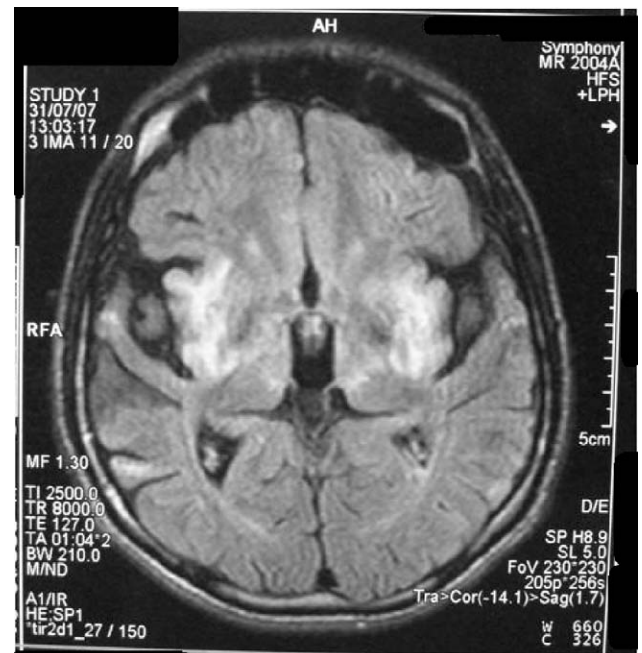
The axial T1-weighted cranial MRI reveals the involvement of bilateral putaminal structures observed as hyperintense signal changes.
